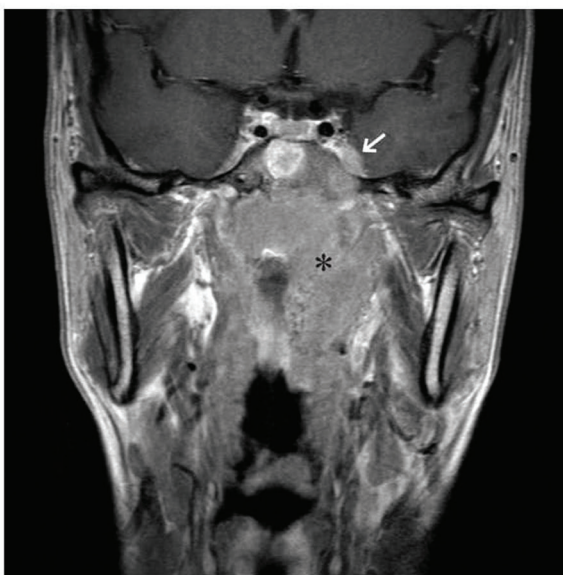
Post-Gd Coronal T1 WFS MRI shows large nasopharyngeal carcinoma (*). Note the small intracranial component the left cavernous sinus (→).
